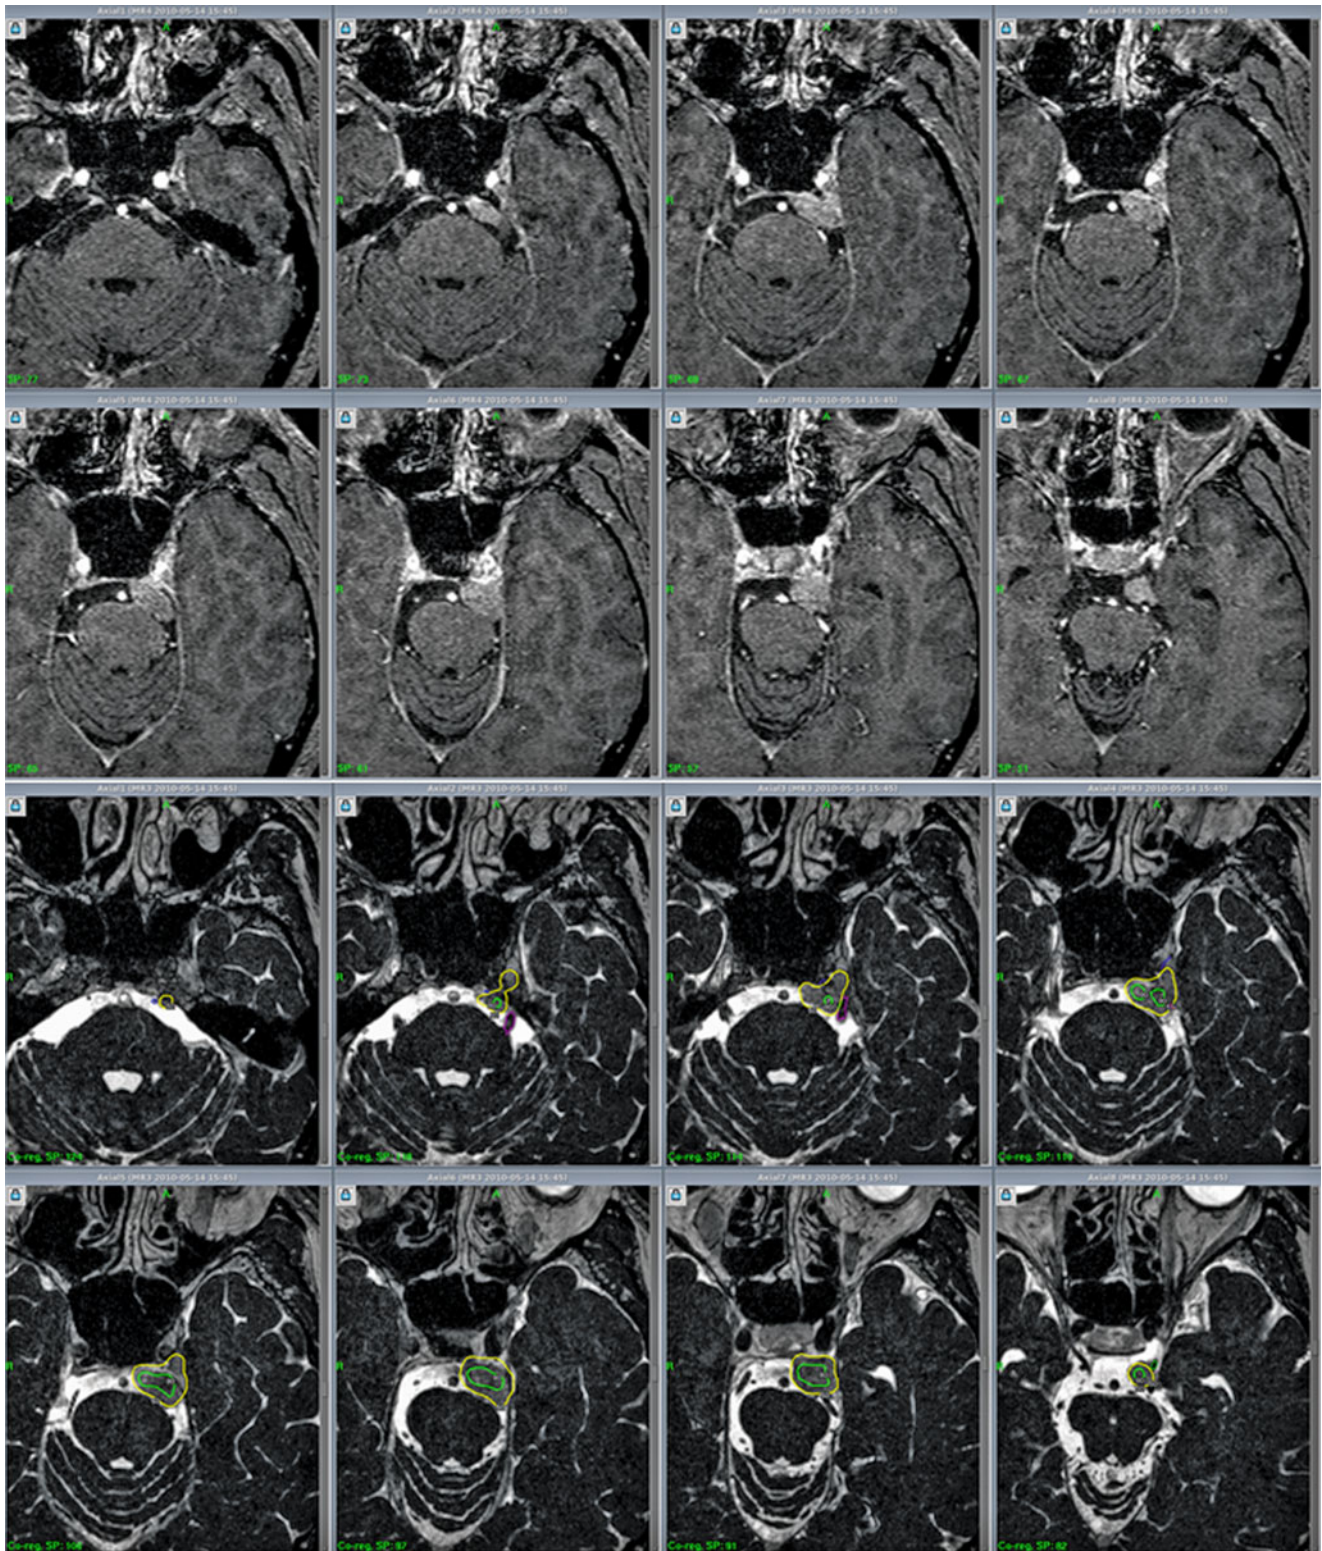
Incidentally disclosed left-sided petroclival meningioma. Gadolinium-enhanced T1-weighted images (*upper*) clearly demonstrated tumor location but did not permit detailed evaluation of the related neuroanatomy. In contrast, gadolinium-enhanced CISS images showed the origin of the neoplasm from the medial part of Meckel's
